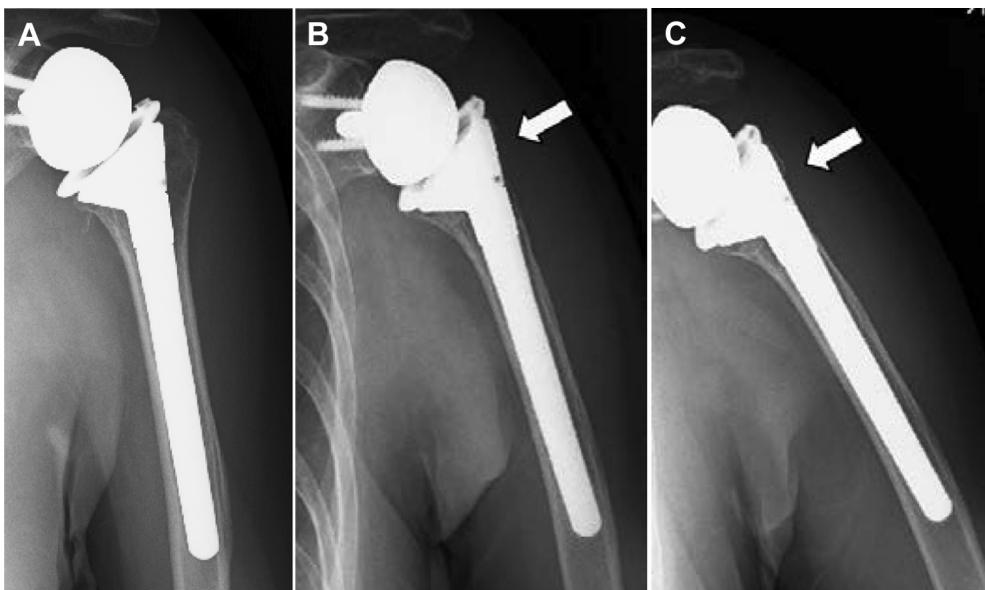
Radiographs obtained immediately (A), at 11 months (B), and at 2 years (C) postoperatively. White arrow, bone resorption area.
